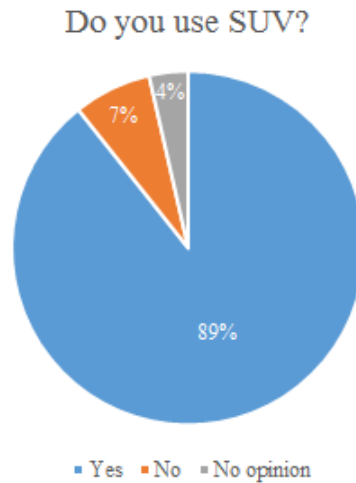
Presentation of the answers to the question: "Do you use SUV?". 89 % answered yes, 7 % answered no and 4 % had no opinion.
